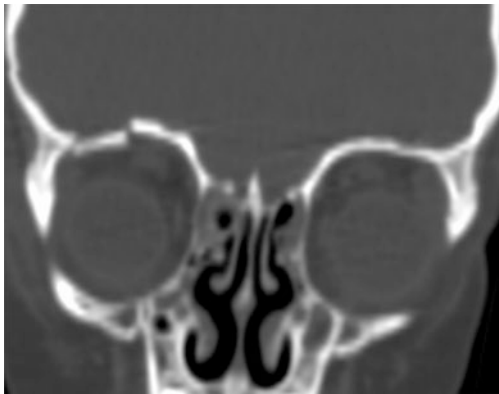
Blow in fracture of the superior orbital wall. Coronal reformatted CT image demonstrates fracture of the superior wall of the right orbit with inferior displacement of the fracture segment into the orbital cavity
